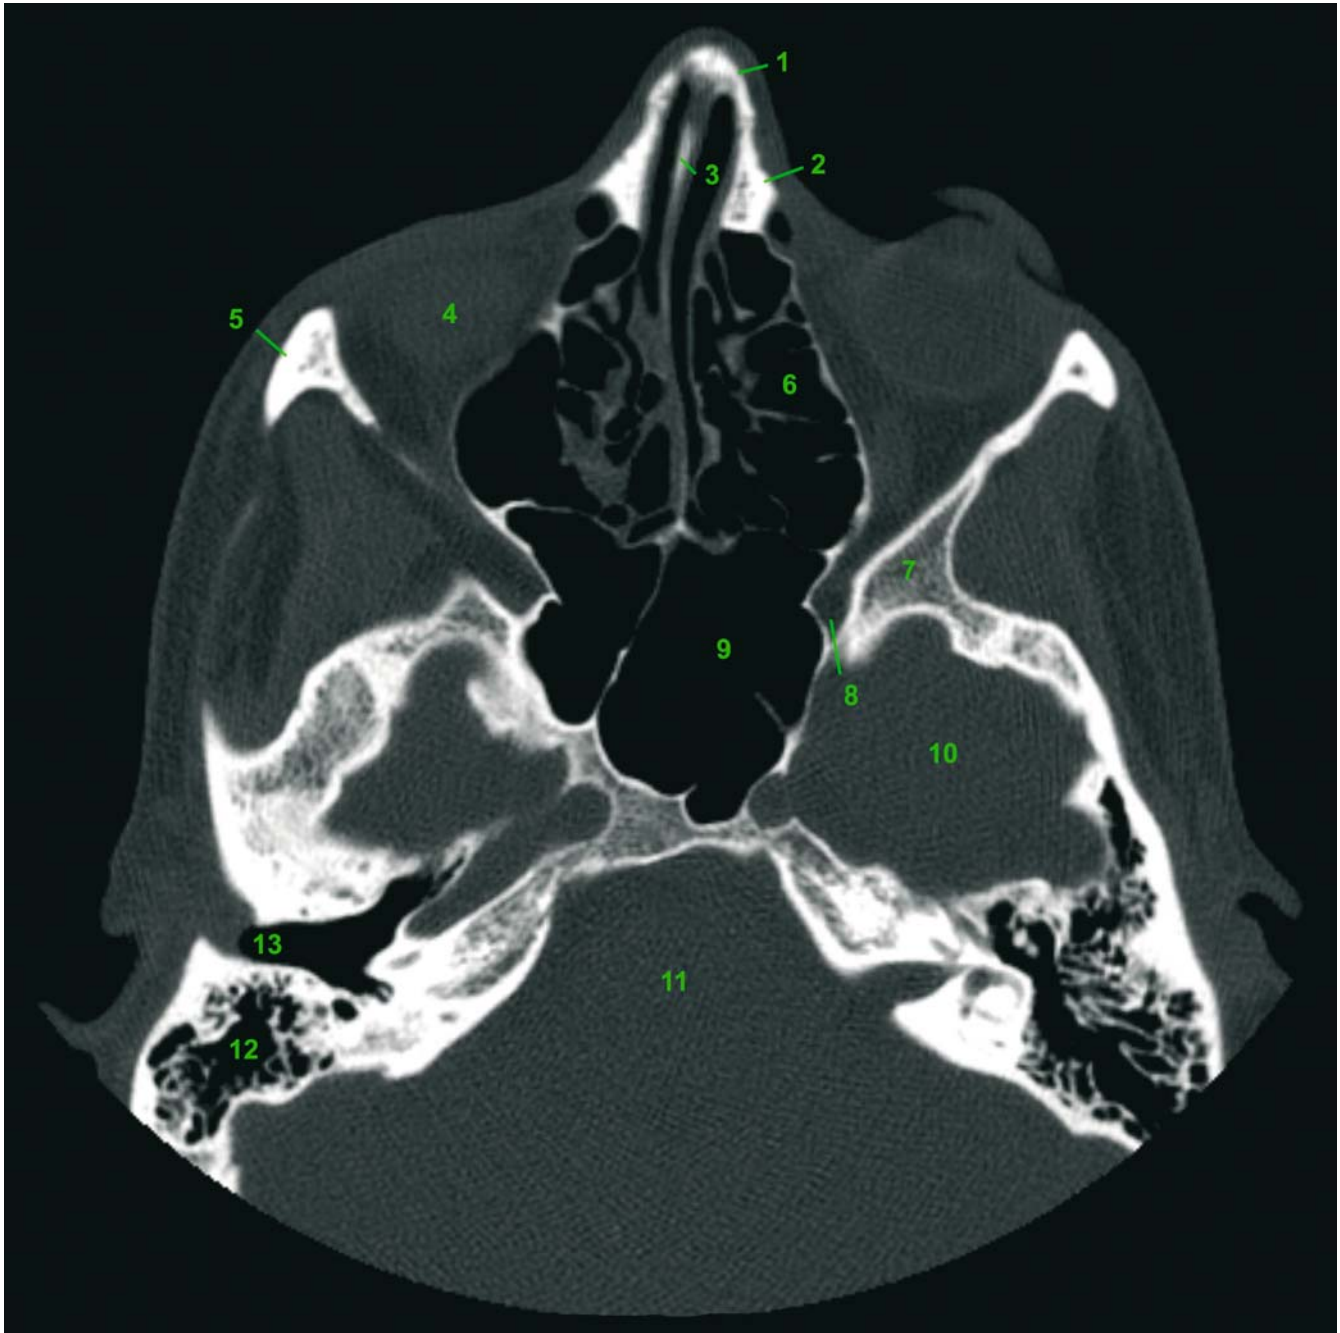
Axial CT slice 4 (patient K.C.). 1 Nasal bone; 2 Maxillary bone; 3 Nasal septum; 4 Orbita; 5 Zygomatic bone; 6 Ethmoidal air cells; 7 Sphenoid bone; 8 Superior orbital fissure; 9 Sphenoidal sinus; 10 Medial cranial fossa; 11 Posterior cranial fossa; 12 Mastoid air cells; 13 External acoustic meatus
